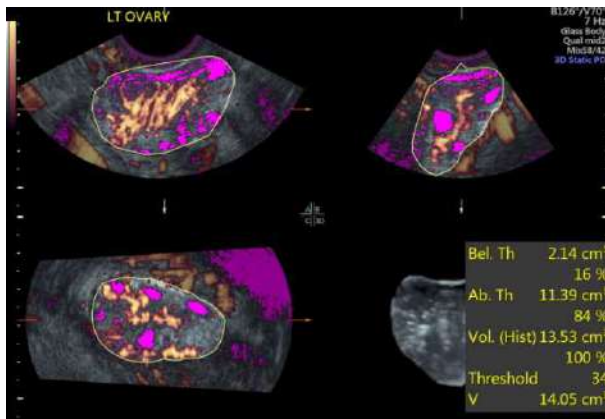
3D power Doppler with volume of the ovary, VOCAL calculation of the same is done and then threshold volume is applied to calculate the stromal volume.
